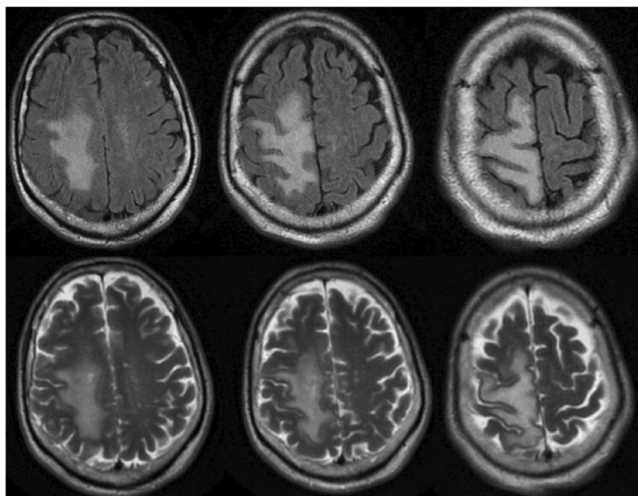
Axial FLAIR and T2-weighted MRI before maraviroc treatment.
